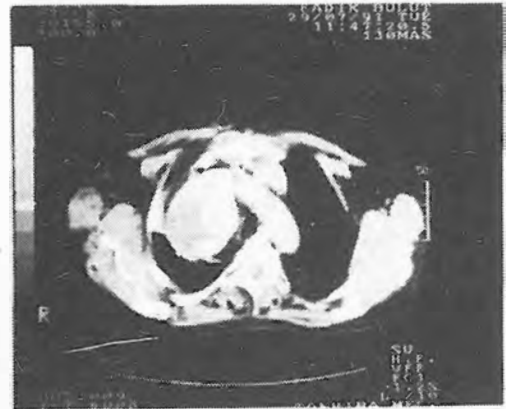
Computed tomography of the chest demonstrating the mediastinal mass causing moderate tracheal compression and deviation
